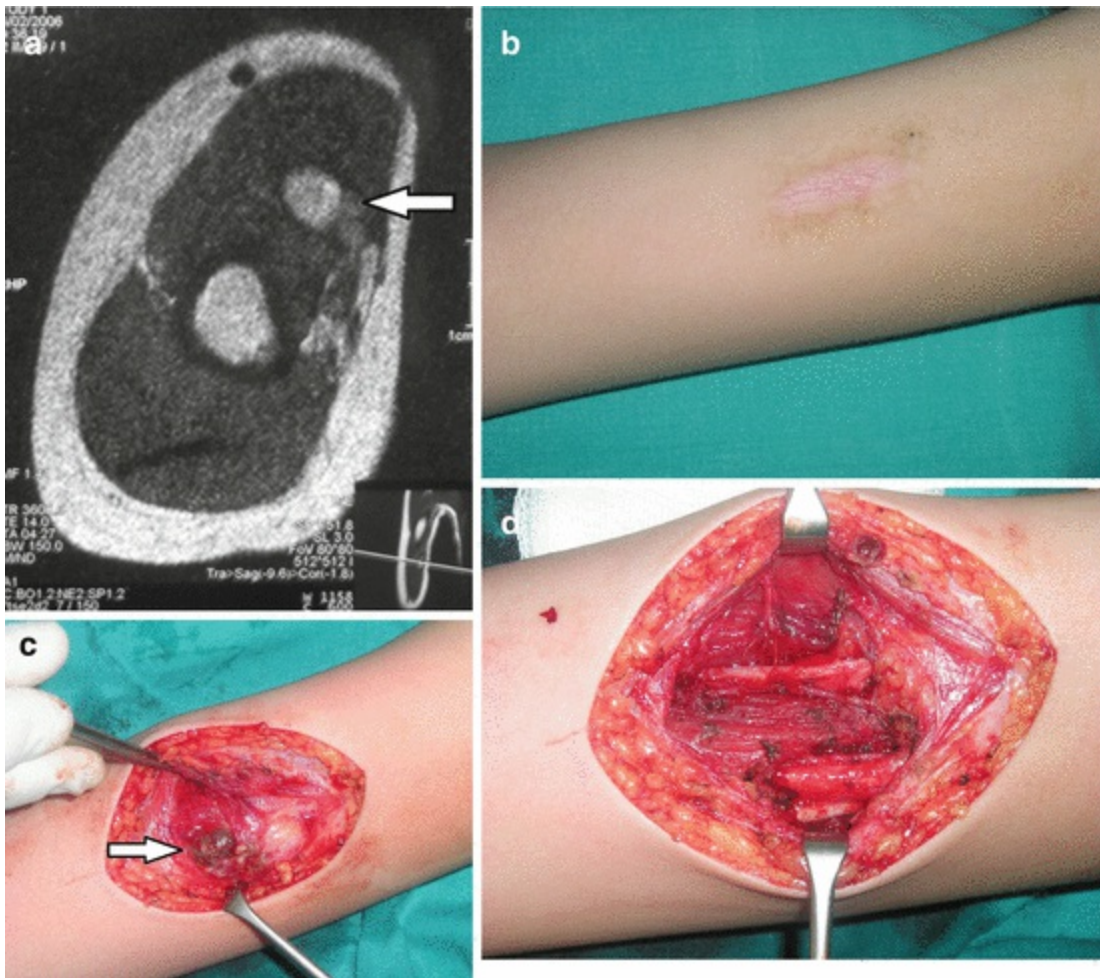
Synovial sarcoma of the right brachial region excision: (a) magnetic resonance imaging finding; (b) preoperative view (the child was previously treated in other hospitals); (c and d) excision of tumor
